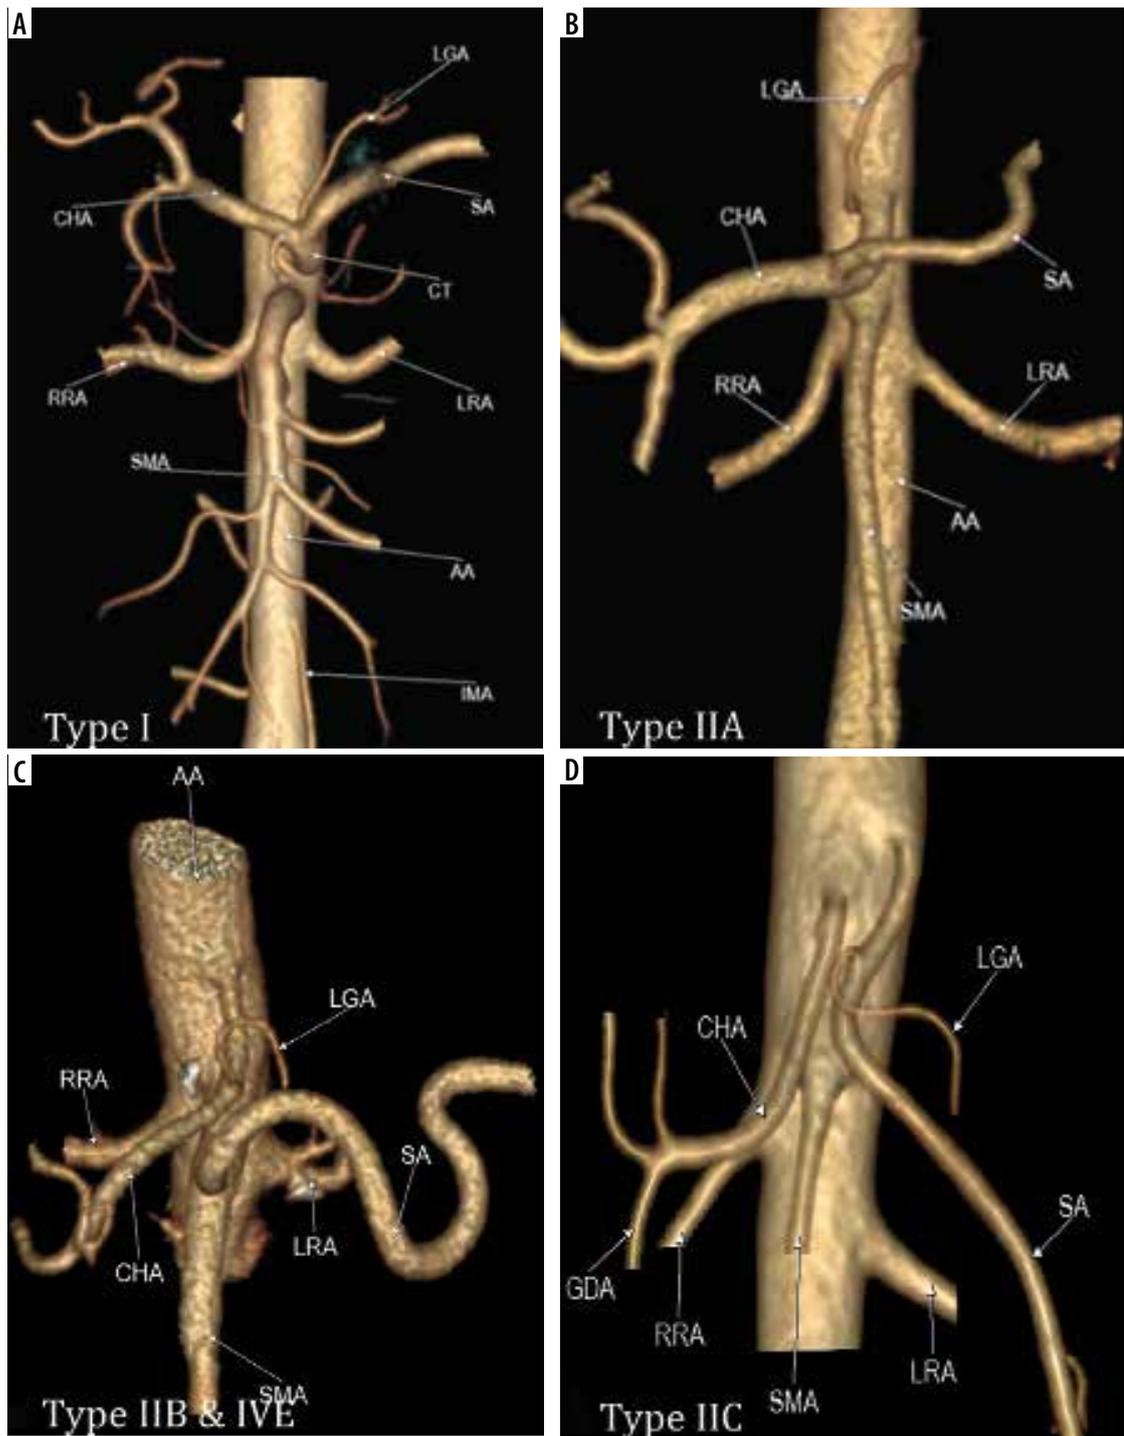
Computed tomography angiography images showing: A) normal trifurcation of celiac artery (Type I), B) hepatosplenic trunk with left gastric artery (LGA) from the aorta (Type IIA), C) hepatogastric trunk (Type IIB) with co-existing splenomesenteric trunk of (Type IVE), D) gastrosplenic trunk with common hepatic artery (CHA) from the aorta (Type IIC)
